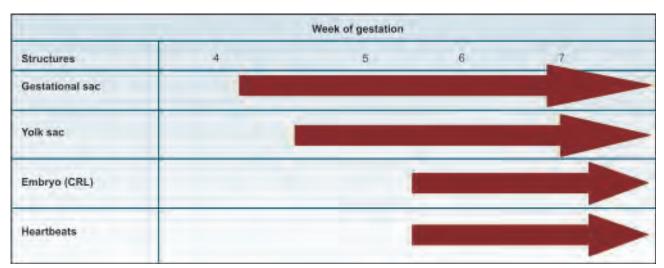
Time of appearance of important developing structures in first trimester as assessed by transvaginal ultrasound
